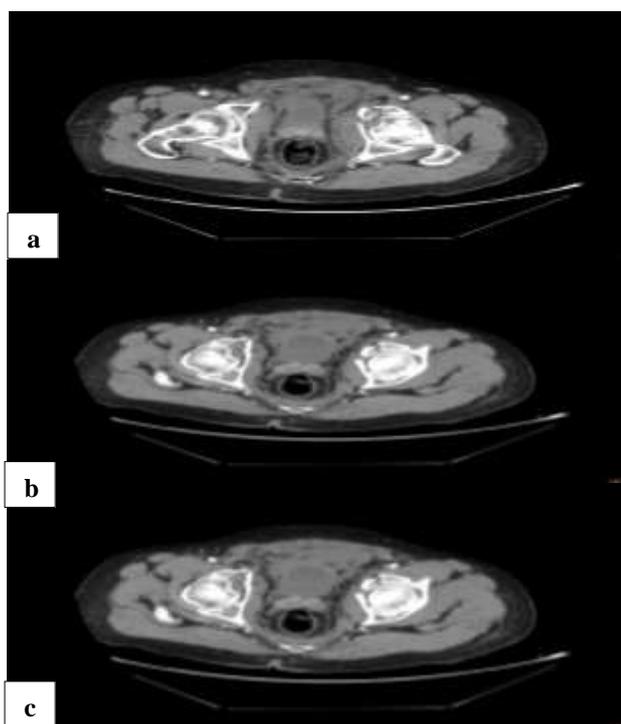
(a), (b) and (c) Axial computed tomography scan of the pelvis confirming the presence of bilateral comminuted acetabular fractures.
